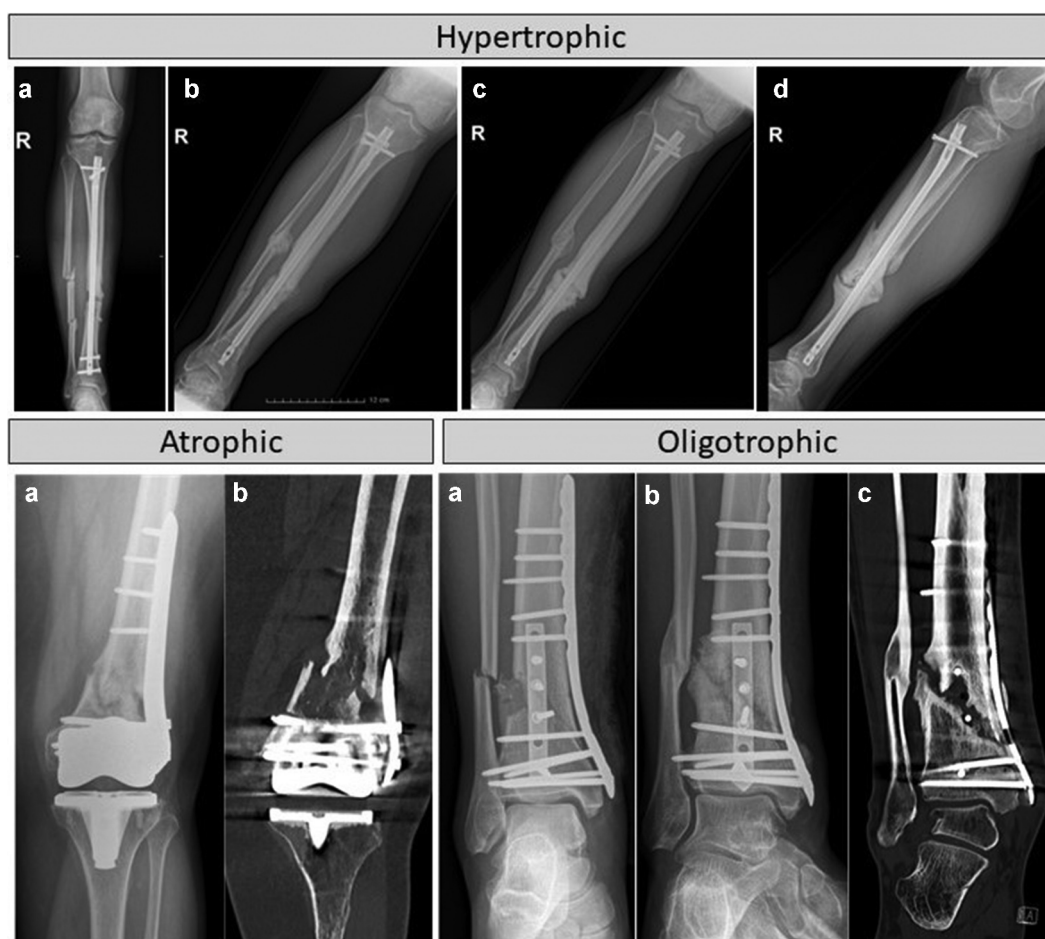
Hypertrophic, atrophic and oligotrophic non-union. (top) a fracture non-union of the tibia in a 43-year-old male patient after the operative treatment of an open tibia and fibula shaft fracture. (a) Anteroposterior radiograph of the tibia immediately after intramedullary nailing. (b) Anteroposterior radiograph of the tibia 8 months after the initial fixation. At that time, the patient reported pain during weightbearing. Therefore, the surgeon suspected a fracture non-union and decided to remove the two distal locking screws (dynamization) (c,d) anteroposterior and lateral radiographs of the tibia 18 months after the initial fixation. A typical hypertrophic non-union with a typical elephant foot shaped callus developed due to instability. (bottom, left) atrophic non-union of a distal periprosthetic fracture of the femur in a 70-year-old woman with total knee arthroplasty and subsequent osteosynthesis of the femur one year previously. (a) The fracture gap at the distal femoral metaphysis is clearly visible on radiographs and there is only minimal callus. (b) Coronal CT image one month later confirms the atrophic non-union, with no substantial callus formation and no osseous bridging. (bottom, right) oligotrophic non-union of a displaced multi-part fracture of the distal tibia in a 42-year-old man. (a) Anteroposterior radiograph of the ankle one day after osteosynthesis of the distal tibia. (b) Follow-up radiograph after one year shows non-union of the tibia with osseous callus on the medial side of the fracture line. The edges of the tibial fracture are sclerotic, and the fracture gap is larger than in the prior image. The laterally displaced distal fibular shaft fracture is fully healed. (c) Coronal CT image on the same day as the follow-up radiograph clearly shows the lack of bridging callus along the sclerotic fracture gap. Note that there is a screw within the non-union fracture gap.
